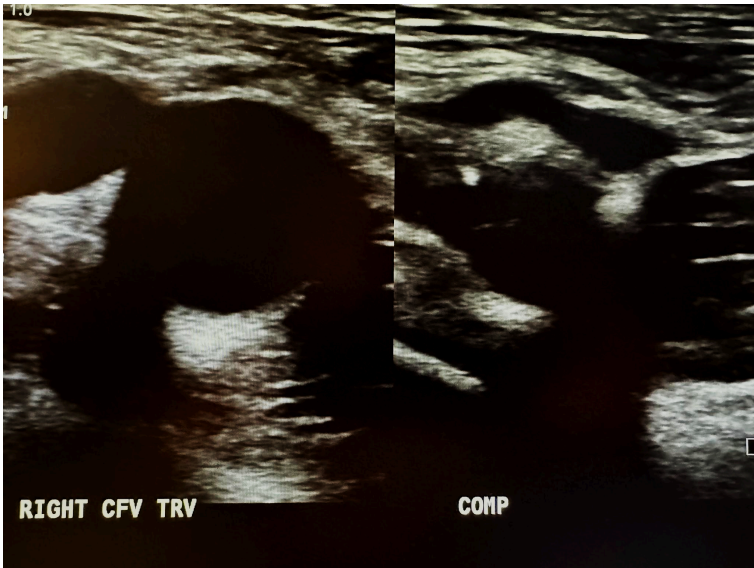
Side-by-side transverse ultrasound views of the right common femoral vein without compression and with compression.
